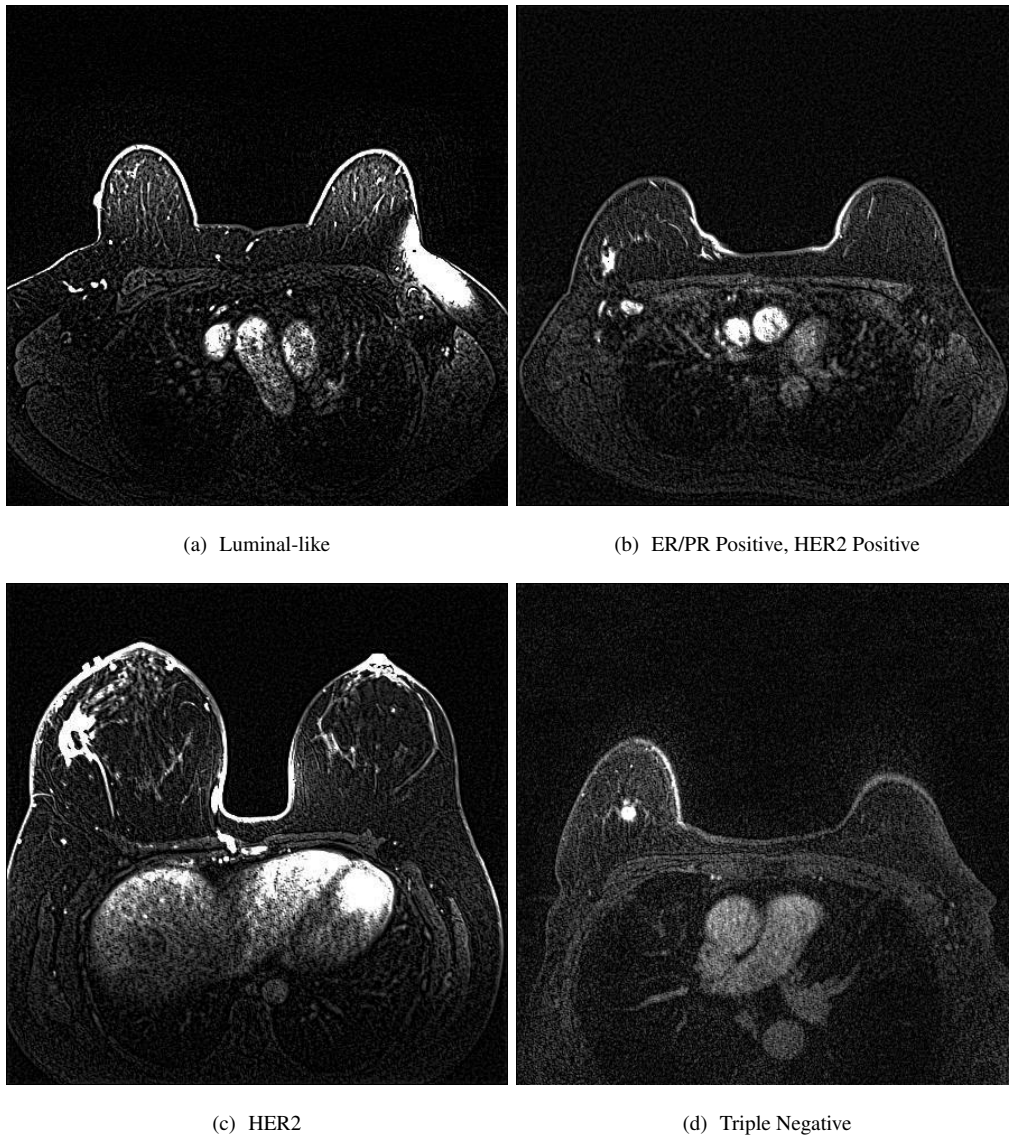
MRI Images of the Molecular Subtypes of Breast Cancer
